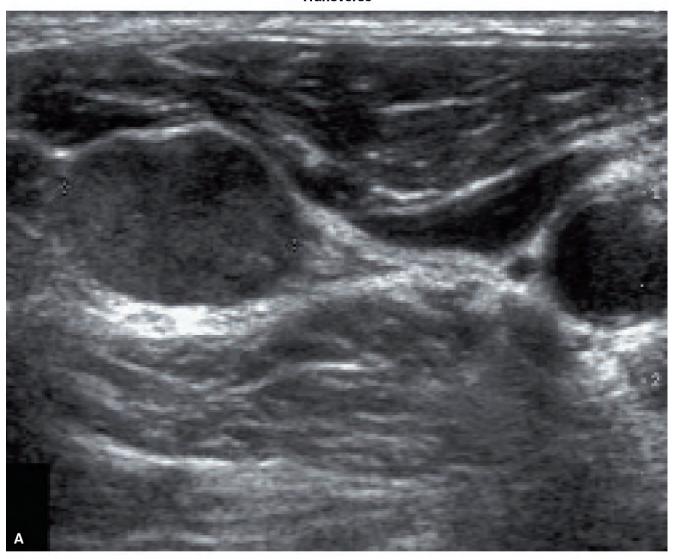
Ultrasound of lymph node metastasis from medullary thyroid carcinoma: right segment 4. A, Transverse, 12×15 mm. B, Color Doppler, Transverse.
